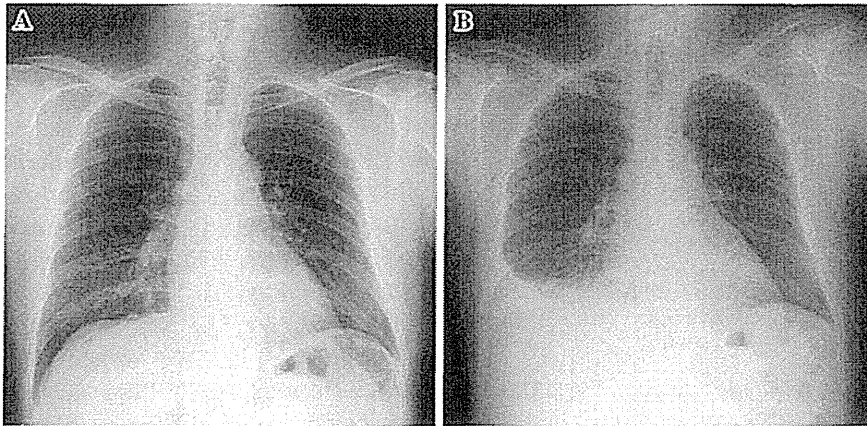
Chest radiographs. (A) Chest radiograph without pleural effusion on day 3 of his illness. (B) Chest radiograph with pleural effusion on the right side on day 5 of his illness.
